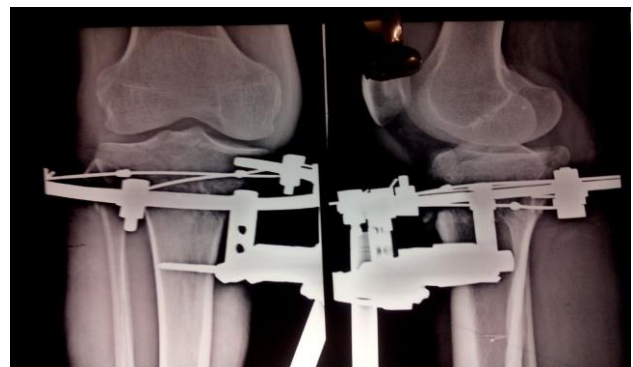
Post-operative radiographs after debridement and hybrid external fixation.
